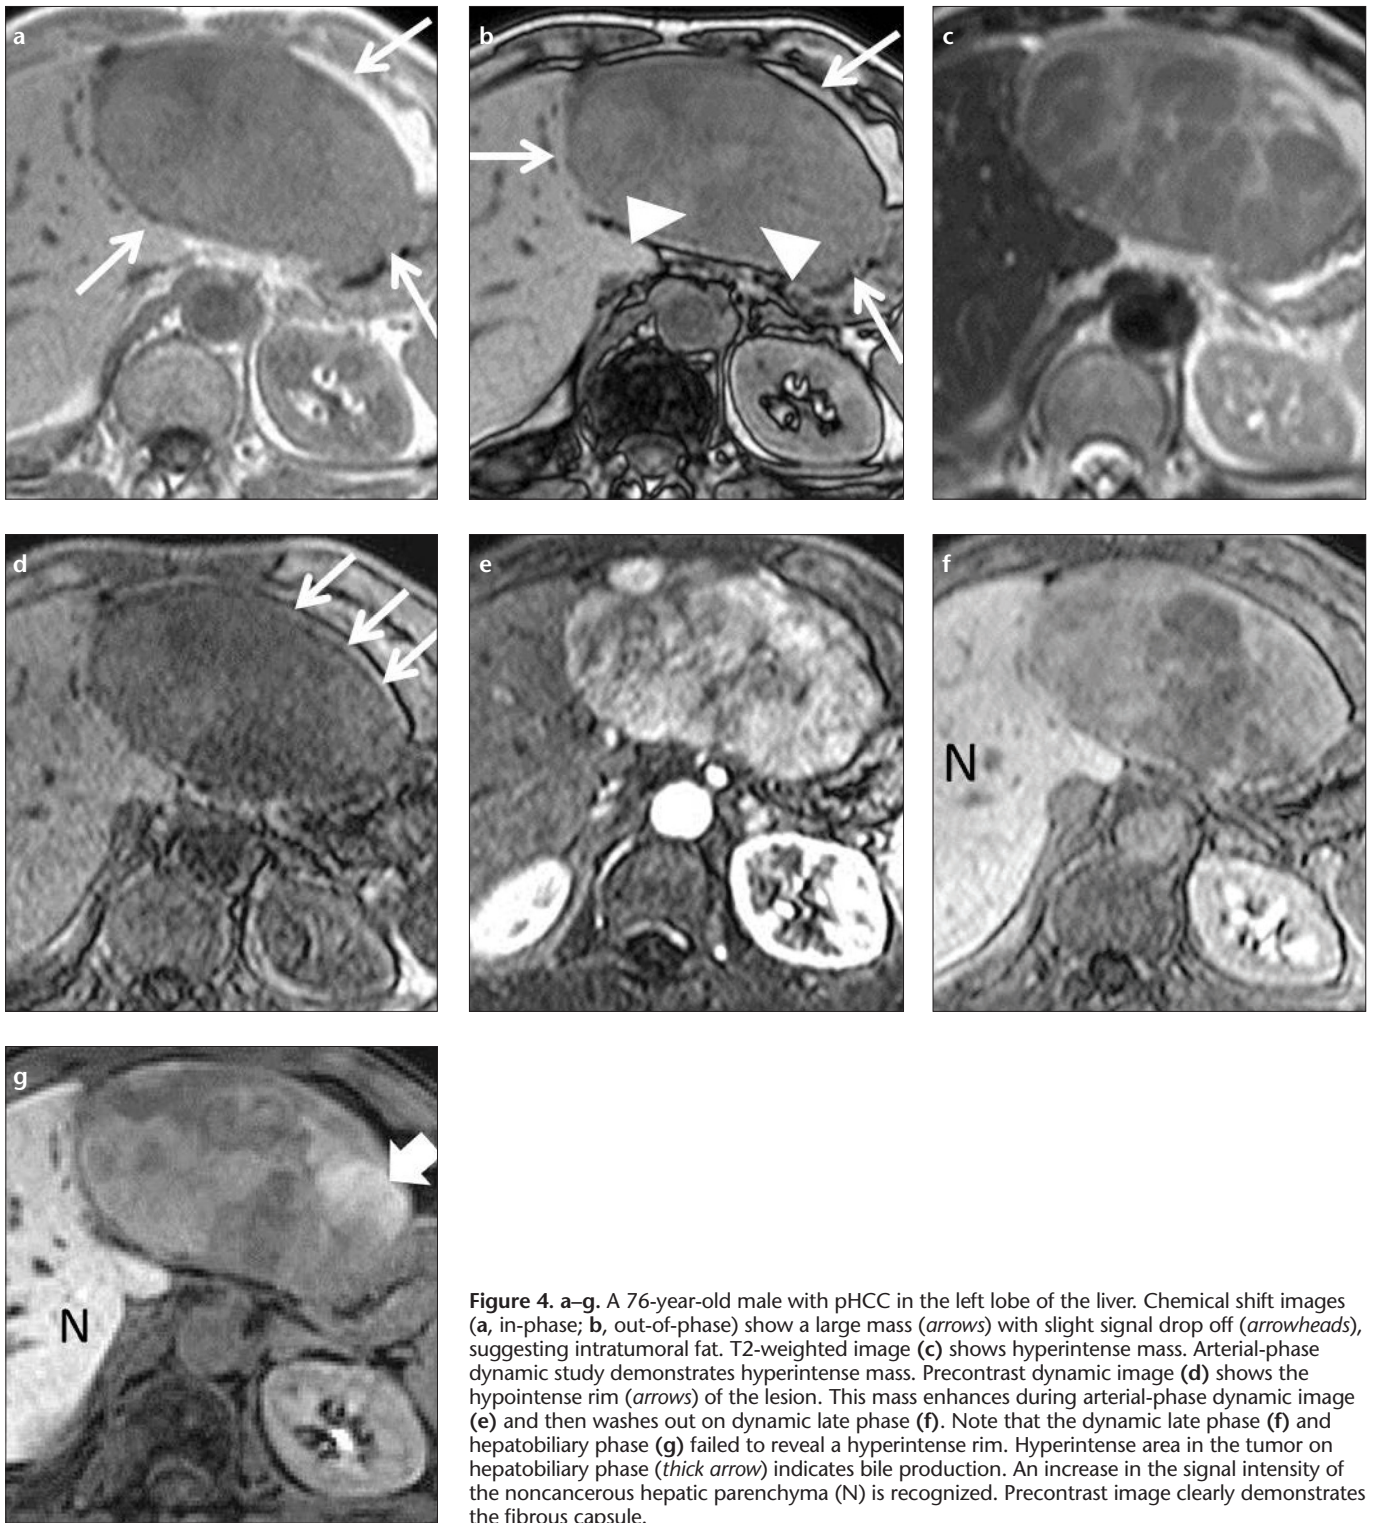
a–g. A 76-year-old male with pHCC in the left lobe of the liver. Chemical shift images (a, in-phase; b, out-of-phase) show a large mass (arrows) with slight signal drop off (arrowheads), suggesting intratumoral fat. T2-weighted image (c) shows hyperintense mass. Arterial-phase dynamic study demonstrates hyperintense mass. Precontrast dynamic image (d) shows the hypointense rim (arrows) of the lesion. This mass enhances during arterial-phase dynamic image (e) and then washes out on dynamic late phase (f). Note that the dynamic late phase (f) and hepatobiliary phase (g) failed to reveal a hyperintense rim. Hyperintense area in the tumor on hepatobiliary phase (thick arrow) indicates bile production. An increase in the signal intensity of the noncancerous hepatic parenchyma (N) is recognized. Precontrast image clearly demonstrates the fibrous capsule.
